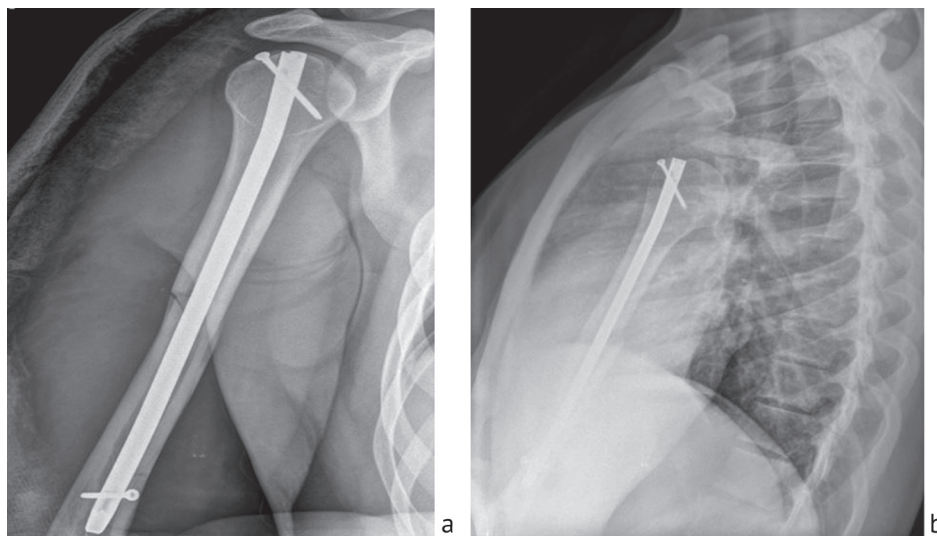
Bone reduction and fixation of the right humerus with interlocking nail shown on postoperative (a) AP view and (b) transthoracic view
